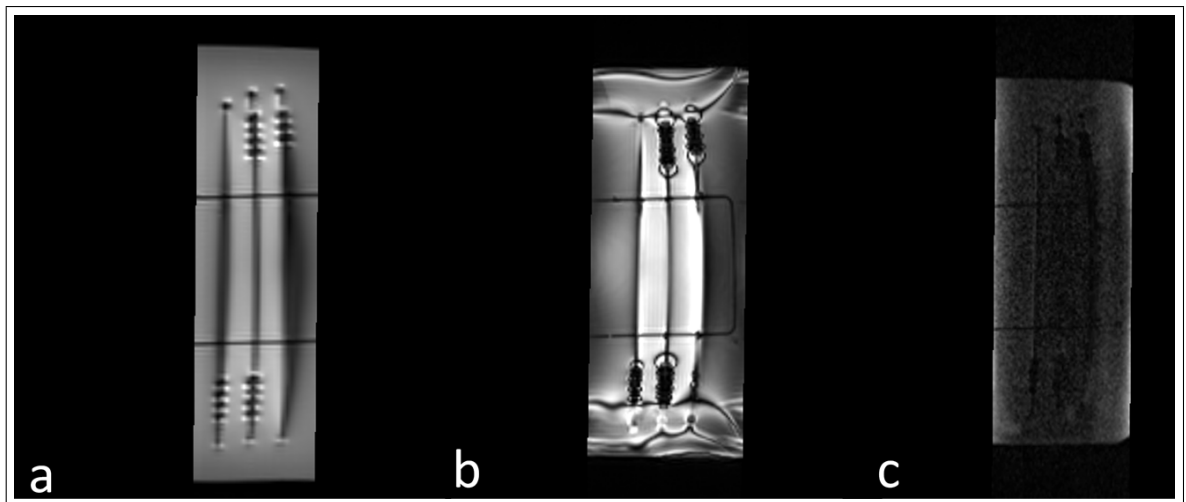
T2 weighted MR images acquired using Turbo Spin Echo (TSE) imaging sequence: a) All nitinol needles that are coated by  $\text{Fe}_2\text{O}_3$  compound with different concentrations (1: maximum concentration 5: minimum concentration) at identical intervals of 5mm, b) image of the nitinol needle with coatings number 3 and 4, c) image (of the nitinol needle with coatings number 3 and 4 for) acquired by changing phase encoding direction and applying water suppression.
